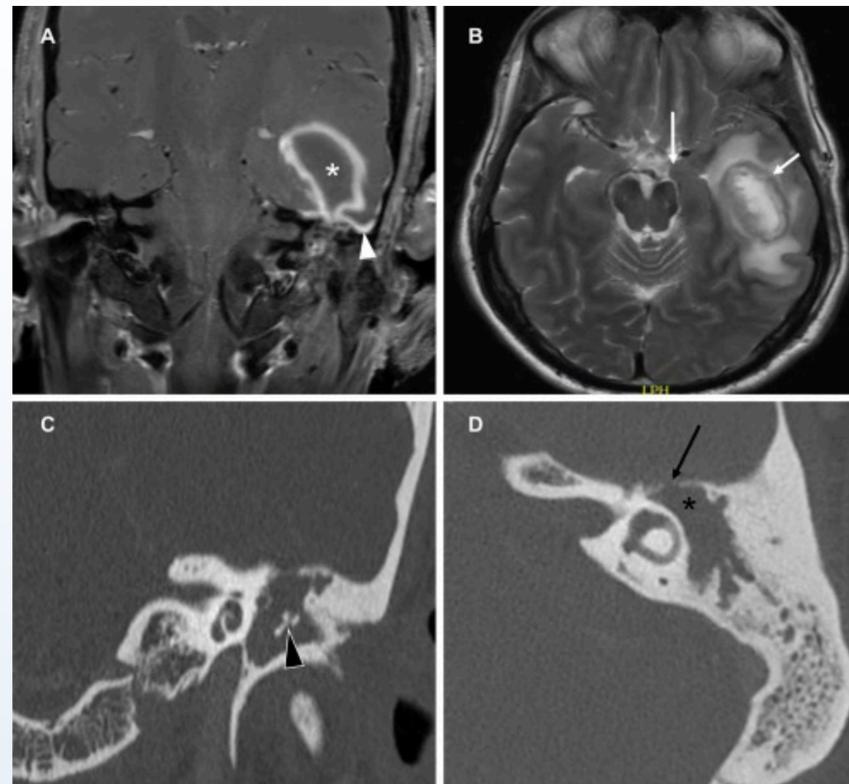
Duarte et al. (2018) published coronal T1 MRI (A) showing lesion in left temporal lobe (white asterisk) with adjacent enhancement of dura (white arrowhead). Axial T2 MRI (B) with hypointensity (small white arrow) surrounding lesion. Coronal CT scan (C) revealed soft tissue mass in left middle ear and mastoid eroding ossicles (black arrowhead). Axial CT scan (D) with erosion of tegmen (black arrow).
